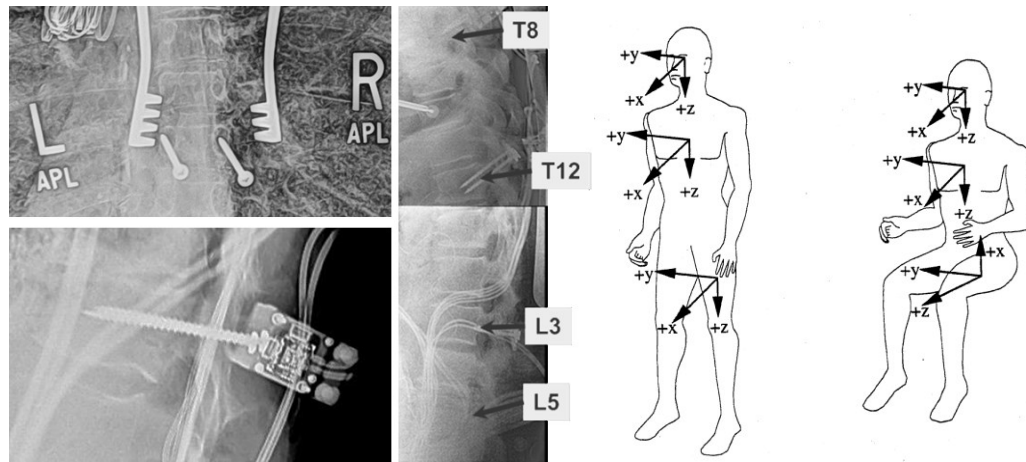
(top left) Frontal X-ray showing metallic pins used to determine location and trajectory of pedicle screws, (bottom left) Lateral X-ray showing installed T12 spinal 6DX block, (middle) Seated X-ray of spinal alignment prior to test execution. (right) Pictorial representation of SAEJ211 coordinate system used for interpretation of body responses. (SAE 2003)
